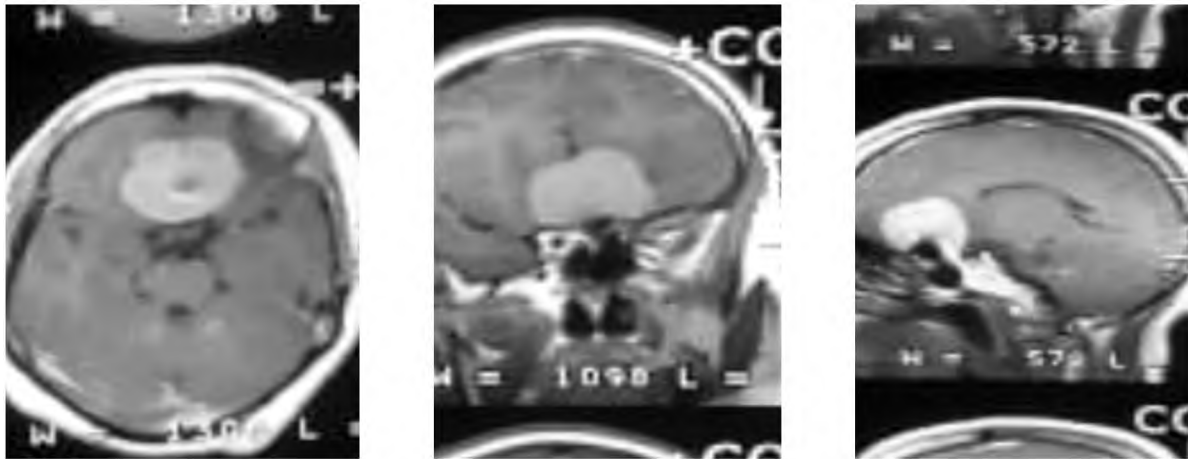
Pre operative MRI with contrast showing planum sphenoidal meningioma.
